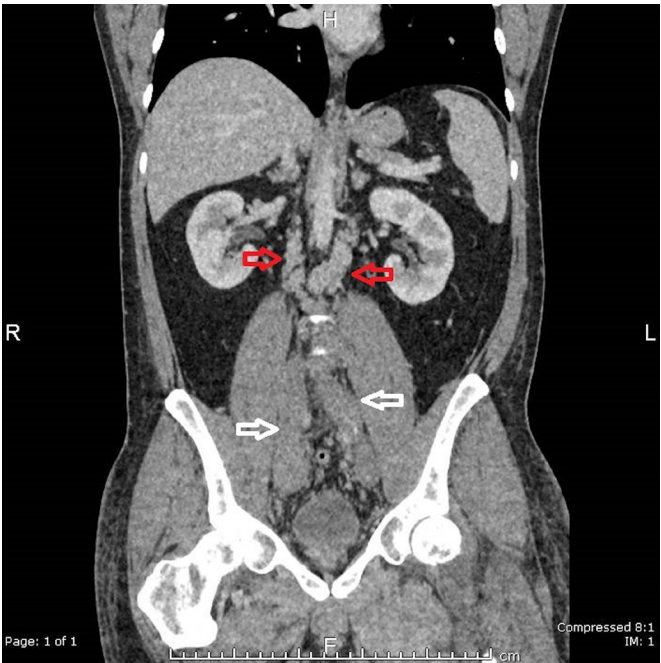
Coronal CT image of the abdomen and pelvis. The white arrows indicate thrombosed iliac veins, the red arrows indicate multiple distended collateral veins.
